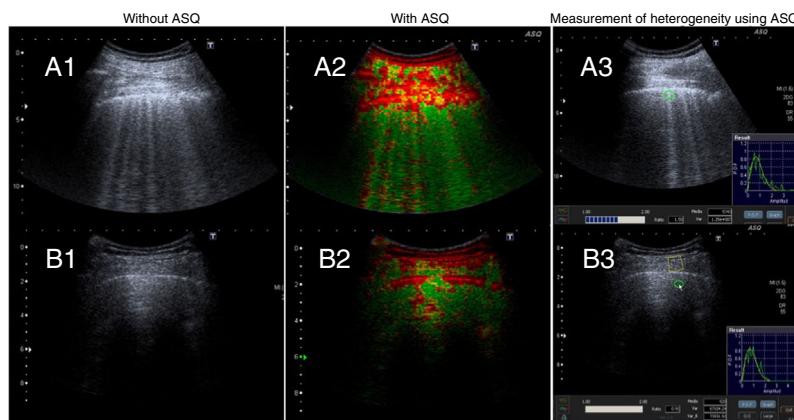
Pulmonary ultrasound without ASQ and with ASQ. Group 1. A1: without ASQ, showing roughness, thickening, and destructuring of the pleural line and multiple B lines. A2 and A3: with ASQ, multiparametric representation and measurement of lung heterogeneity, respectively. Group 2. B1: without ASQ, showing normal, fine pleural line, B lines (less than 3) and A lines. B2 and B3: with ASQ, multiparametric representation and measurement of lung heterogeneity, respectively.
